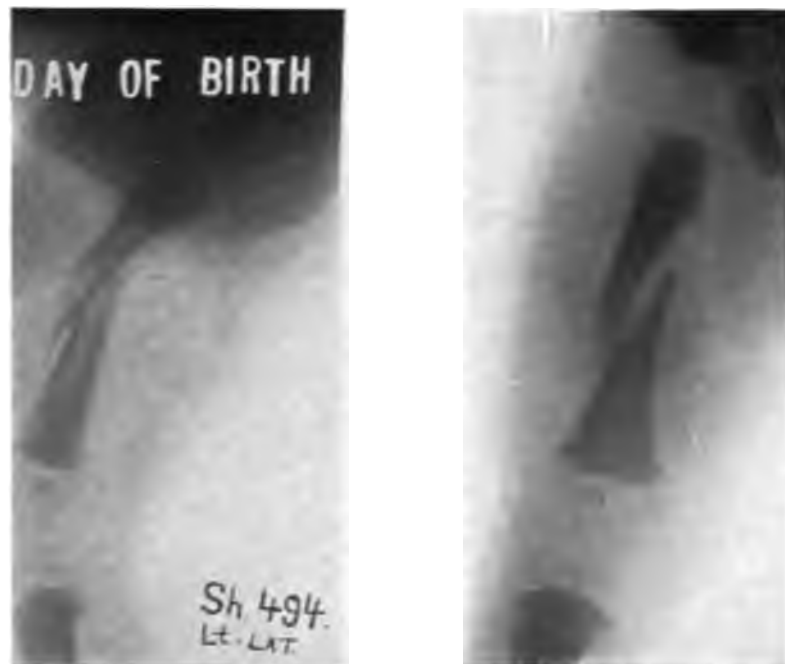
Case 4. Fresh fracture of the femur roentgenographed on the day of birth. The oblique line of fracture crossed the femur at the center of the shaft of the bone. The front view showed separation of the fragments, the lateral an anterior angulation.
